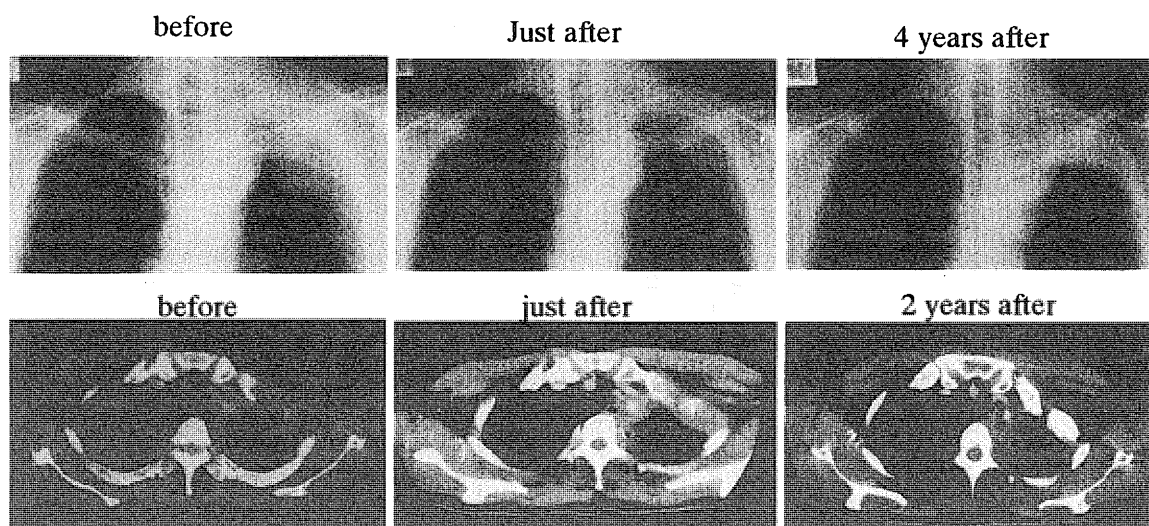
A change in chest X-ray findings and CT images in a 50-year-old male with squamous cell carcinoma of the lung treated with hyperthermia combined with radiation therapy.
